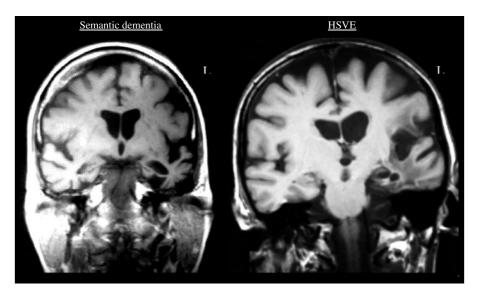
Example coronal MRI for SD versus HSVE. These two example coronal slices show the typical nature and type of disease-specific damage shown on structural MRI. It should be noted, however, that the distribution of damage for both HSVE and SD varies across patients from bilateral damage through to strongly right or left lateralized (as shown here).
